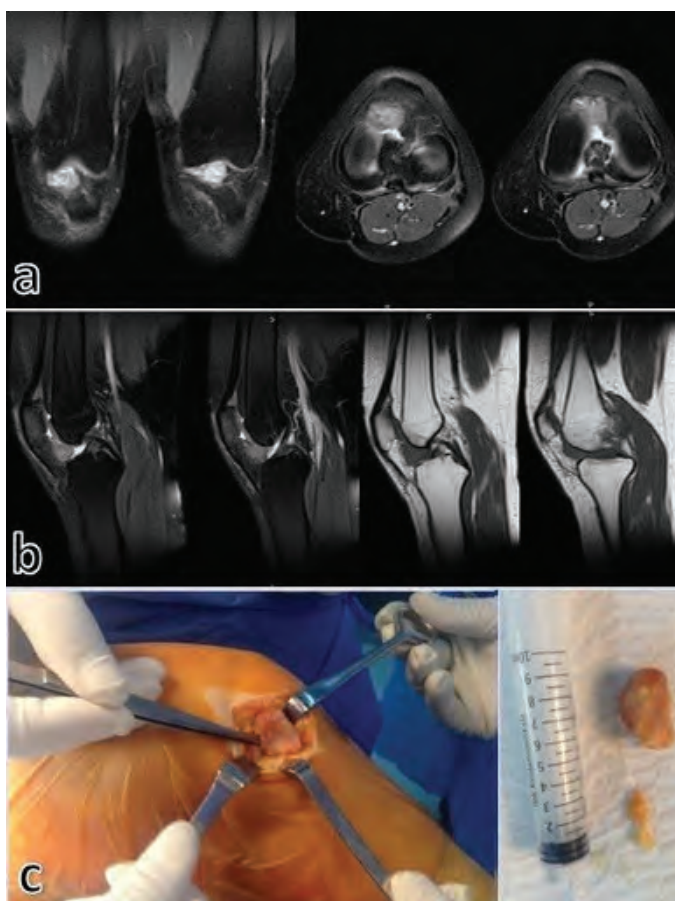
GCTTS of the left knee. (a) View on the coronal and axial sections of the MRI T2-weighted sequences, heterogeneous slightly high signal intensity of the tumor. (b) View on the sagittal sections of the MRI T2 fat-suppressed (moderate signal) & T1-weighted (low signal) sequences. (c) Perioperative image of excisional biopsy of the lesion and macroscopic views of the mass and its pedicle (size: 4x2.5x1.5 cm) (the patient provided written informed consent for print and electronic publication of the figures)
